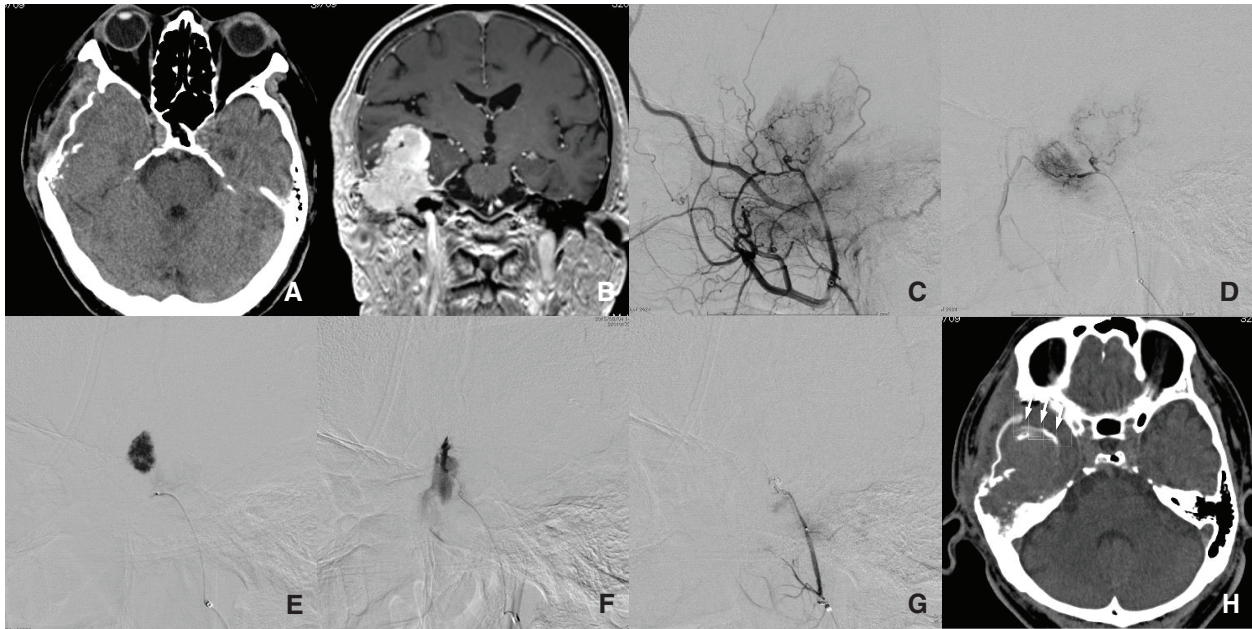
Recurrent meningioma at the middle cranial fossa. (A) Brain CT shows a large iso-density mass at the right middle fossa. Bone defect of the right temporal bone due to previous surgery was noted. (B) Coronal image of post-contrast T₁-weighted MRI shows a markedly enhanced mass at the right middle cranial fossa. The mass invaded into the infratemporal fossa with destruction of the skull base. (C) Lateral view of the left external carotid angiography shows the interruption of the right MMA due to previous surgery and numerous small feeders originating from the proximal portion of the MMA, accessory meningeal artery, and deep middle temporal artery. (D) Selective
